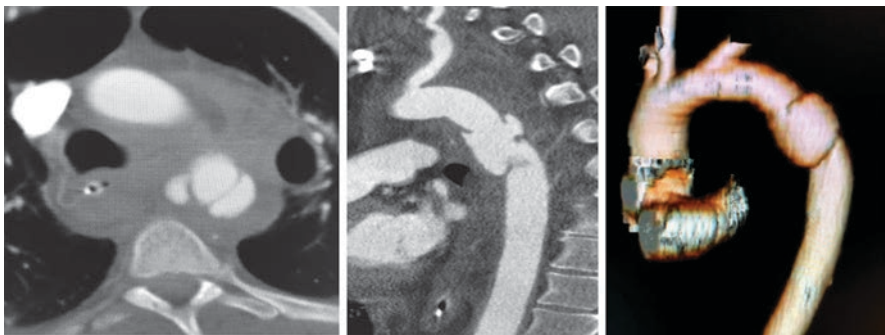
From left: Axial, parasagittal, and reconstructed images from a computed tomographic angiogram of the chest, demonstrating a severe (Grade IV) blunt thoracic aortic injury
